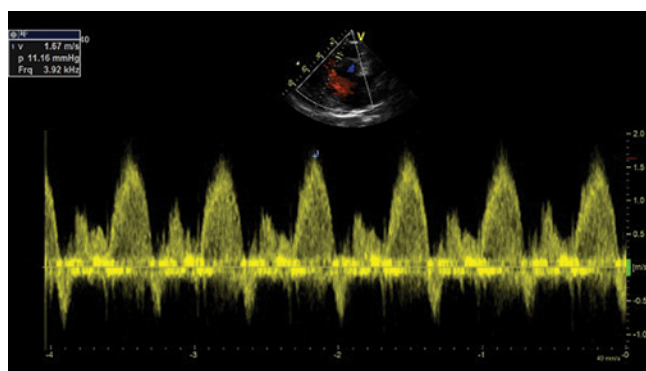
Velocity of the flow recorded simultaneously with spectral Doppler does not exceed 1.67 m/s – residual maximum gradient of 11 mmHg
